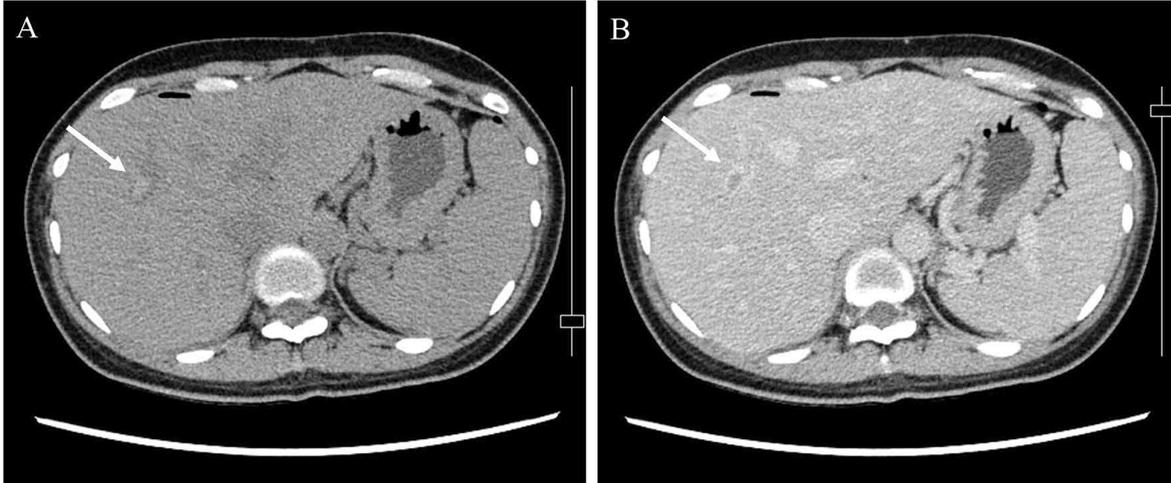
Contrast-enhanced CT (at the diagnosis of portal vein thrombosis)
